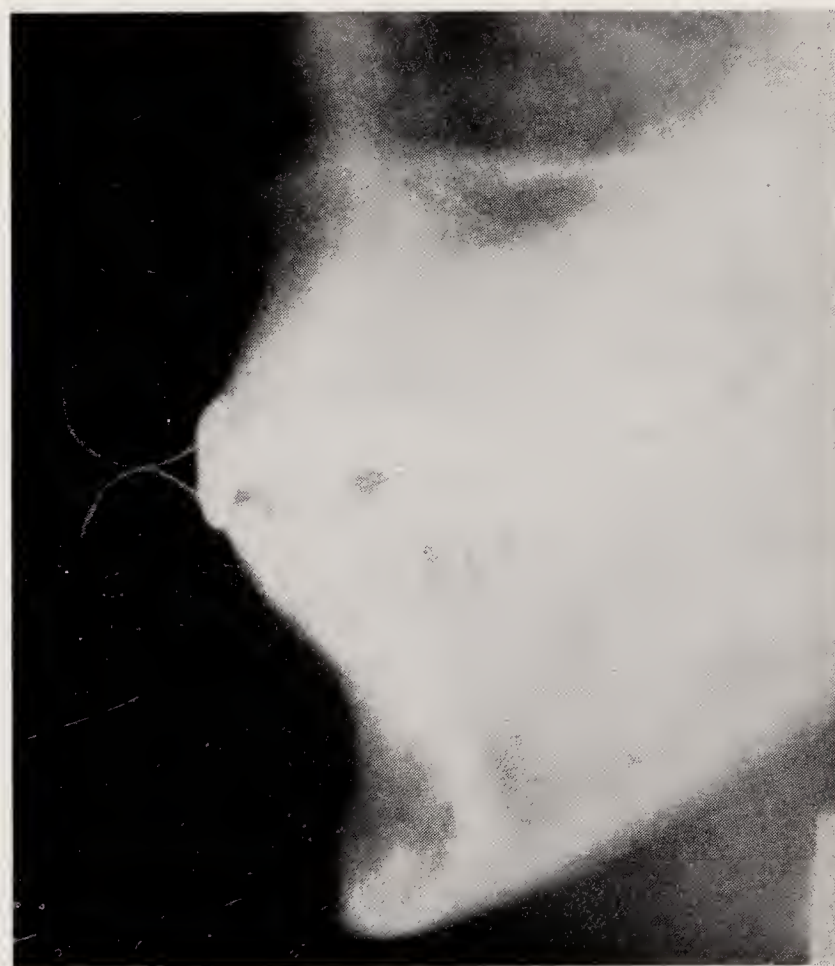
An example of a profile X-ray with barium paste, showing up the surfaces of the lips in the midline.
